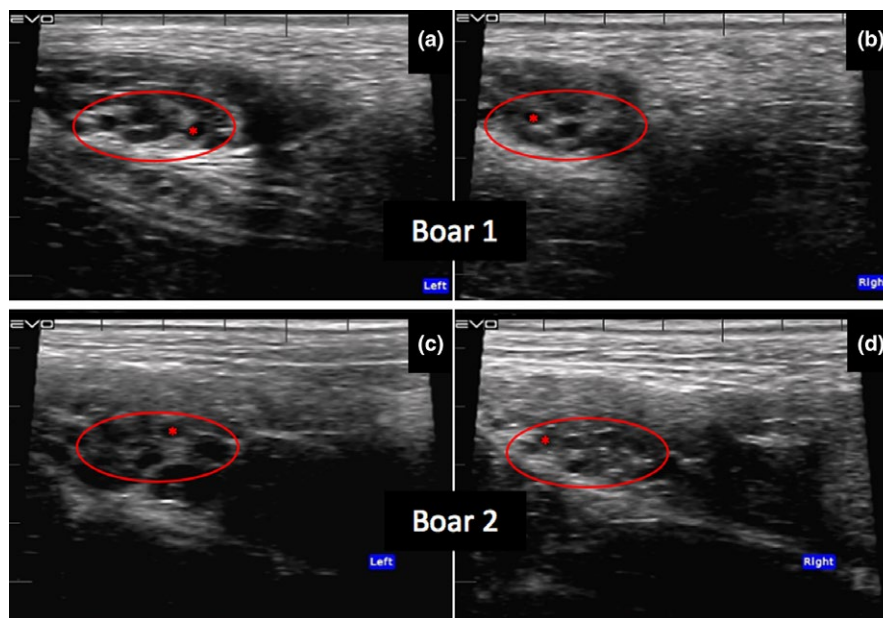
Ultrasound images of a boar without varicocele (Boar 1) and a boar with varicocele in the left pampiniform plexus (Boar 2). Red ovals on each ultrasound image indicate the cross section of the pampiniform plexus (PP) vessels. One representative vessel per image is identified with an asterisk (*). Using the Bioquant image system, the area (mm²) of 3 to 10 vessels of the PP was measured and the average area of right PP vessels (AAR) and of the left PP vessels (AAL) was derived. Panels a and b represent the left and right PP vessel images for a boar, respectively. The left and right vessel ratios (AAL/AAR or AAR/AAL, respectively) of Boar 1 were <1.5; therefore, the boar was identified as non-varicocele. Panels c and d are representative images from a boar (Boar 2) with varicocele in the left plexus (AAL/AAR >1.5)
